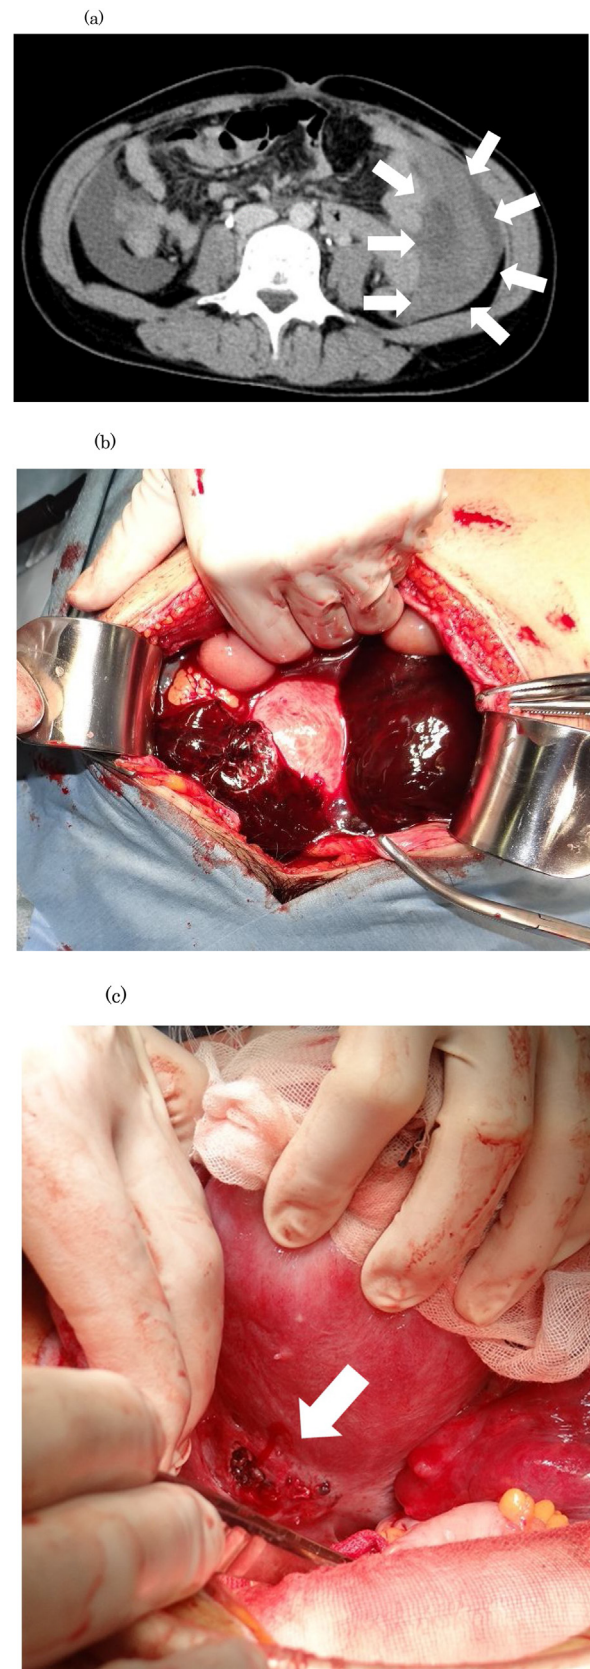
(a) Computed tomography showing intraperitoneal free fluid with partially high signal. (b) Massive hematoma in the abdominal cavity. (c) The lower uterine posterior wall was ruptured.
